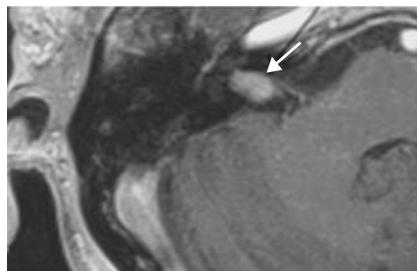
A gadolinium enhanced T1-weighted MRI scan showing a 10 mm acoustic tumour (arrow) confined to the internal auditory canal. This patient presented with a sudden hearing loss on the tumour side.
